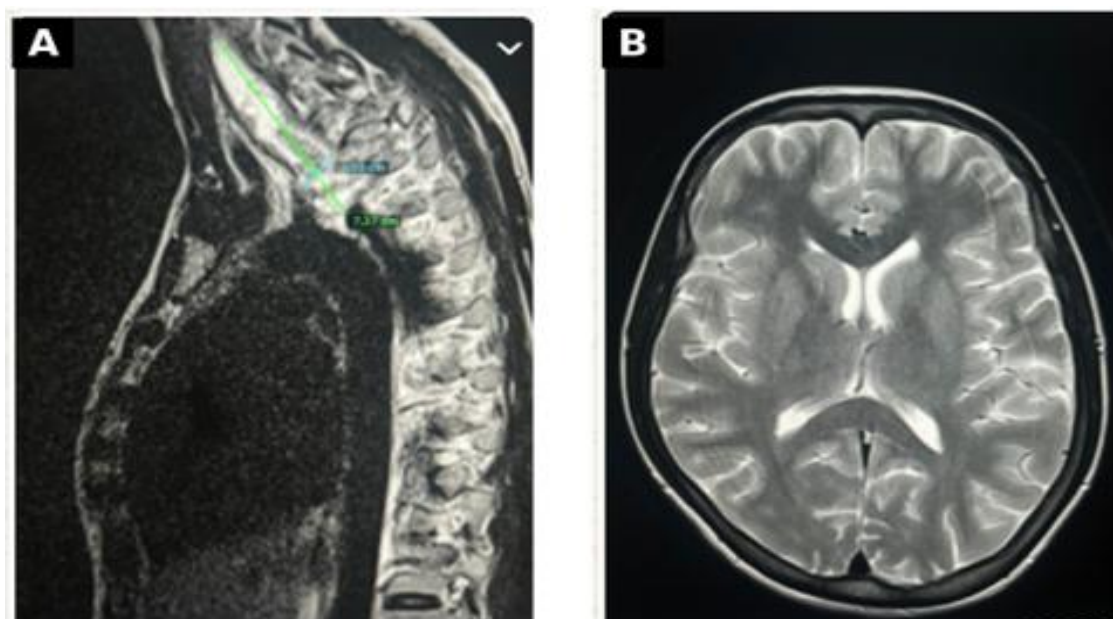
(A) Sagittal spine MRI showing collapse of the D2 vertebral body with gibbus deformity and measured prevertebral/epidural collection producing cord compression and (B) axial MRI brain image showing no significant intracranial abnormality.
